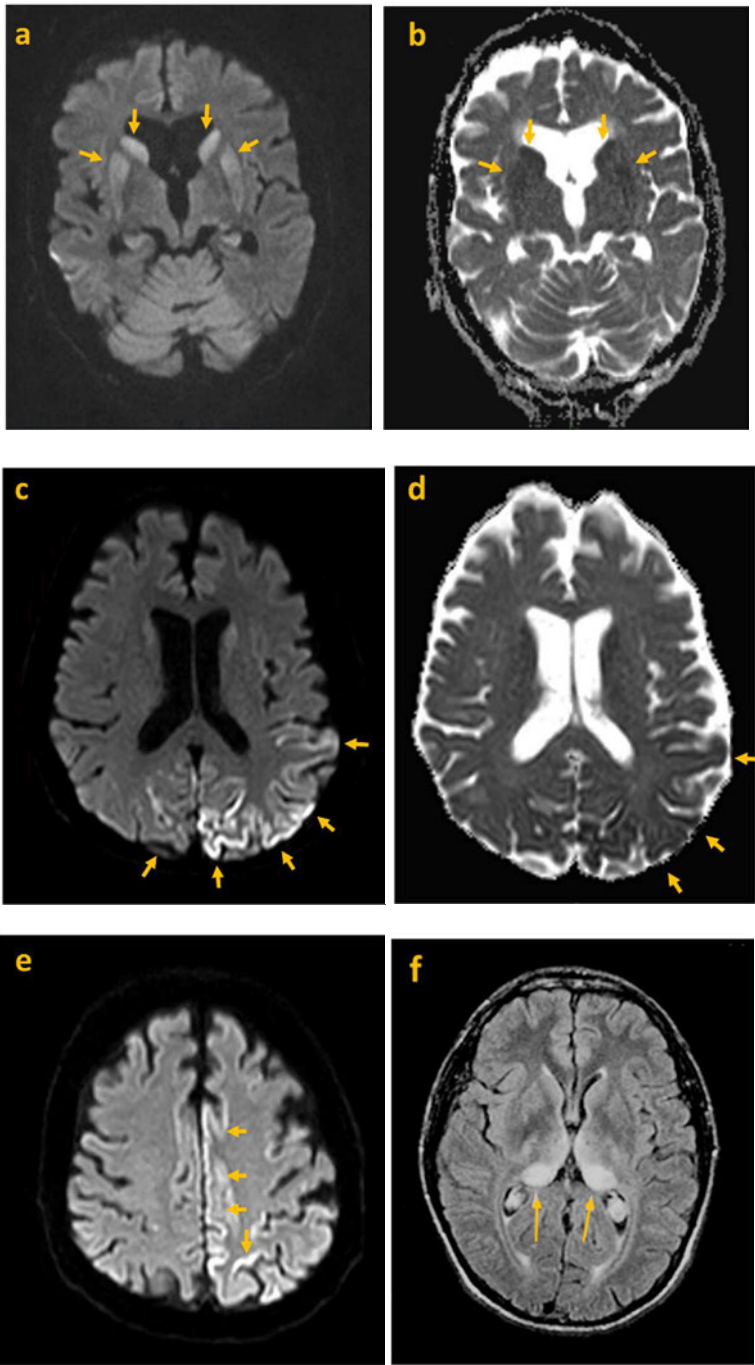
MRI in Creutzfeldt-Jakob disease (CJD)
